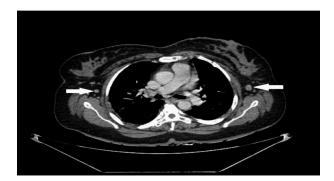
CT SCAN OF CHEST: showing bilateral enlarged axillary lymph nodes (Arrows).
